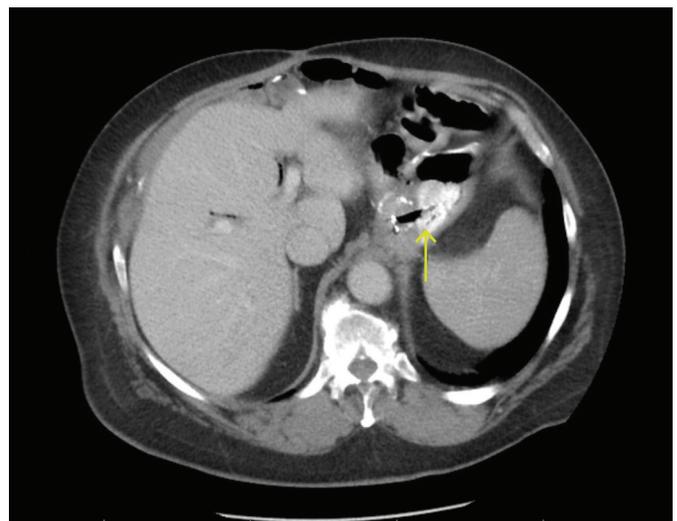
Computed tomography of the abdomen showing the gastrogastric conduit via a metal stent (arrow) and a decompressed gastric remnant.
